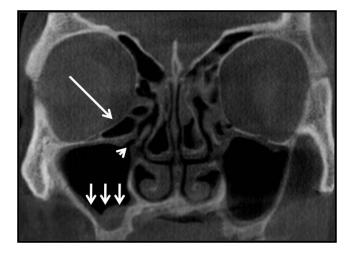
Coronal cone beam CT shows, Haller cell causing thinning of bone of orbital floor (long arrow), compression of infundibulum of left maxillary sinus (arrow head), thickened mucosa of left maxillary sinus (short arrow)
